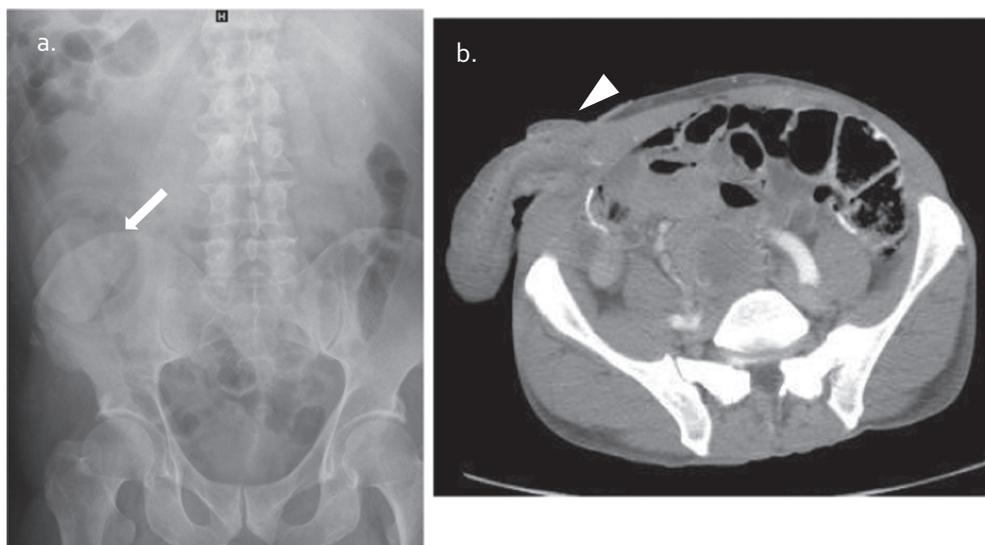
Stomal prolapse: frontal abdominal radiograph (a) demonstrates stomal prolapse presenting as a soft tissue mass surrounded by air at the colostomy site (arrow). Prolapse is easily identified on axial CT (b) (arrowhead).
